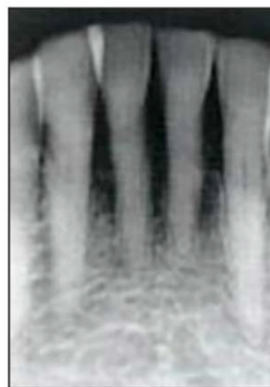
Periapical radiograph of pulp sclerosis in the mandibular anterior teeth.
